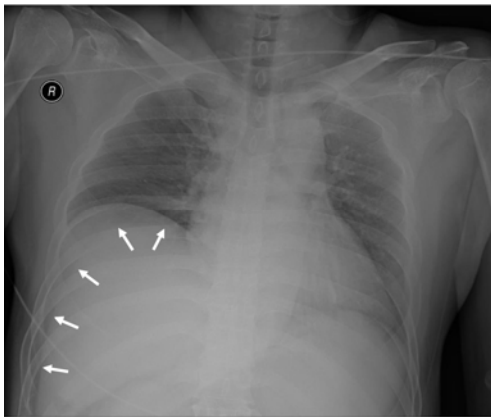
Supine chest radiography shows a radiolucent lesion separating the liver and right hemidiaphragm (white arrow).
